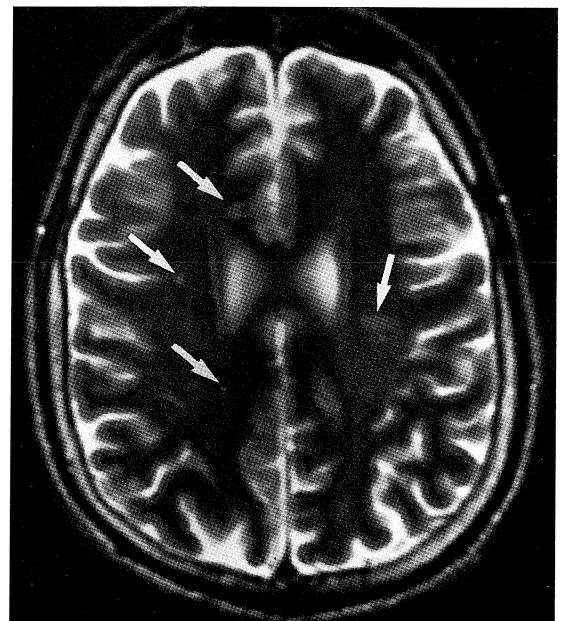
Axial T2-weighted MR images showing multiple, bilateral punctate lesions (arrows).
